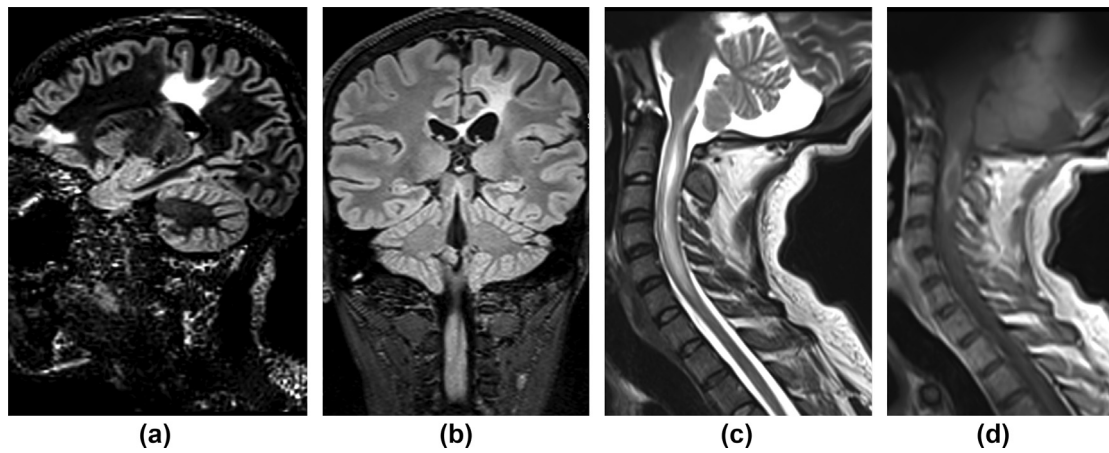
Demyelinating lesion mimicking tumour. (a) Sagittal double inversion recovery and (b) coronal FLAIR images show multiple demyelinating lesions in frontal and parietal lobes. (c) On sagittal T2WI there is a hyperintense lesion centred at C2–C3 levels with accompanying cord expansion. (d) Contrast-enhanced image shows rim enhancement. Both intracranial and spinal lesions responded to medical therapy.
